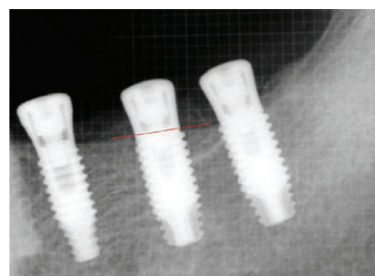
Periapical radiograph taken immediately after implant placement. In the #36 area, an implant, 4.8 mm in diameter and 10 mm in length, was placed. The crestal bone level in the vicinity of implant was considered as the baseline.
